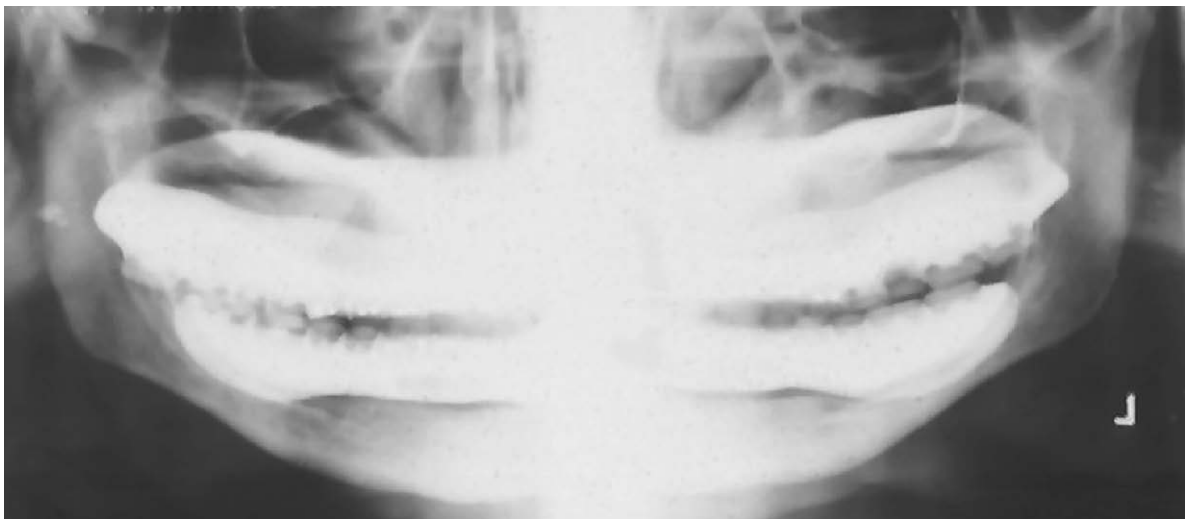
Where denture bases are radio-opaque the denture should always be removed prior to panoramic radiology being performed. Otherwise the primary image of the denture base will exclude necessary details from the interpretation
